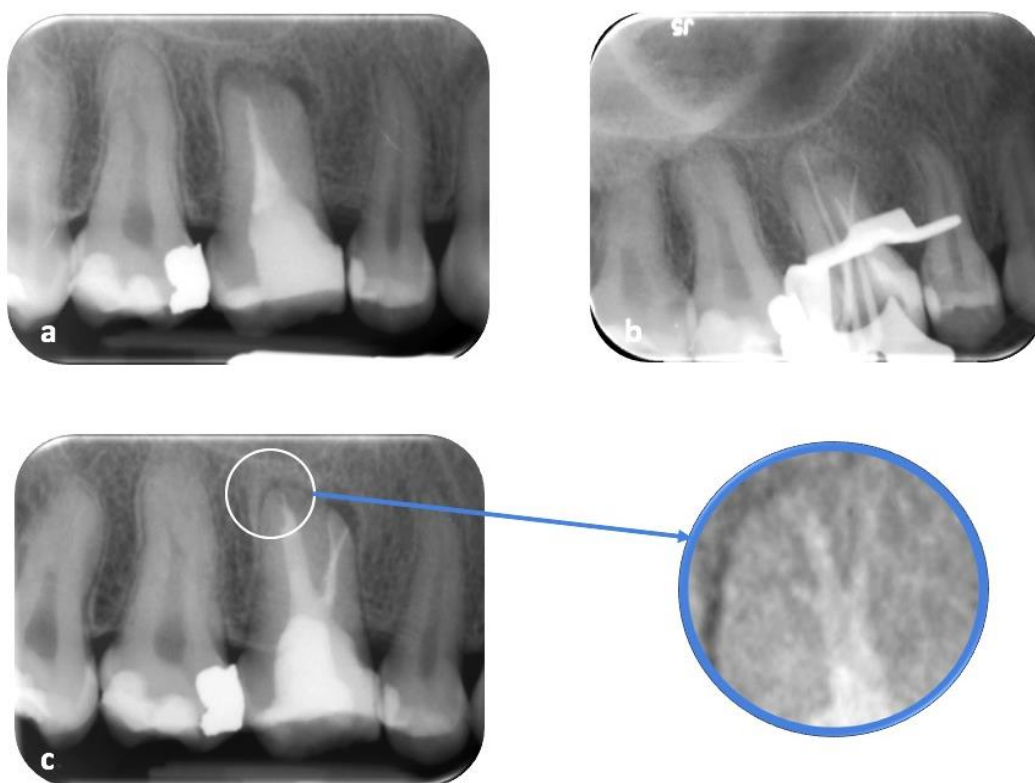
PA radiographs of tooth 16 (a) Pre-operative (b) Master cone of tooth (c) Postoperative radiograph, highlighting apical delta
